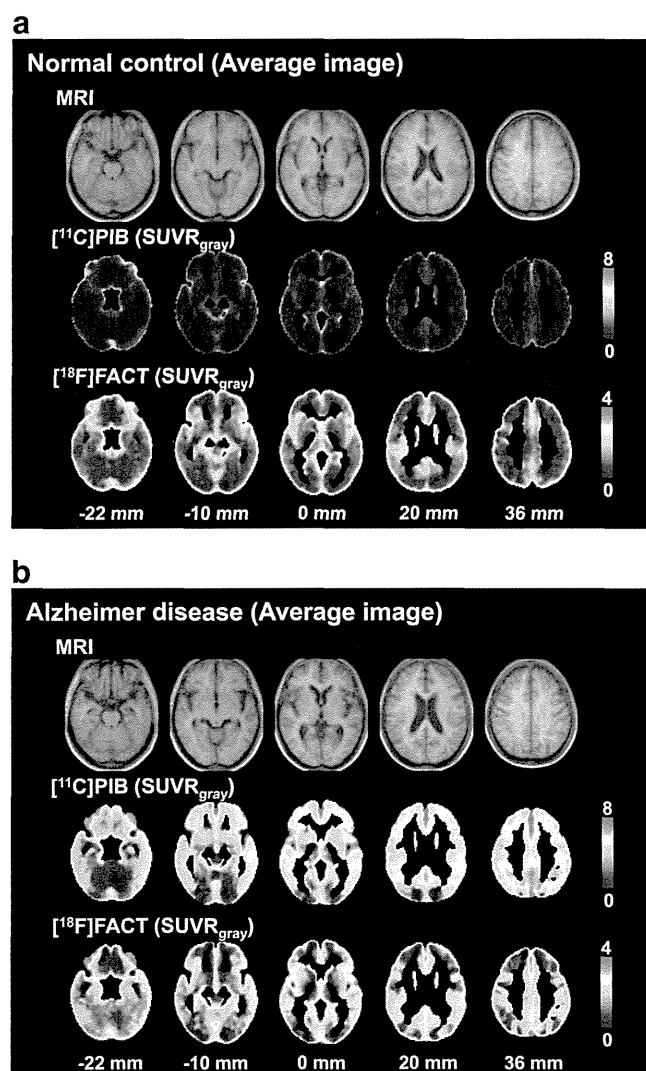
Average images of SUVR in gray matter ($SUVR_{gray}$) of [^{11}C]PIB and [^{18}F]FACT studies and corresponding average MR images (T1-weighted images) for normal control subjects (a) and AD patients (b). Scale maximum and minimum values are 8 and 0 of $SUVR_{gray}$ for [^{11}C]PIB and 4 and 0 for [^{18}F]FACT studies. All images are transaxial sections parallel to the anterior-posterior commissure (AC-PC) line. Slice positions are -22, -10, 0, 20, and 36 mm from the AC-PC line. Anterior is at the top of the image and the subjects' right is on the left
